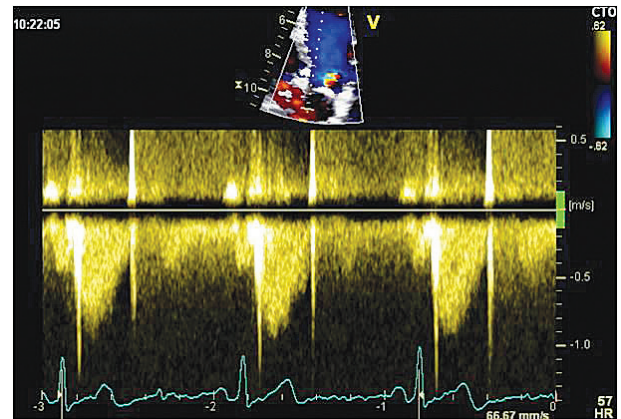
Magnified view of the LVOT; (A) 2D image, (B) with color, (C) LVOT flow on PW Doppler (see text for abbreviations and description).
